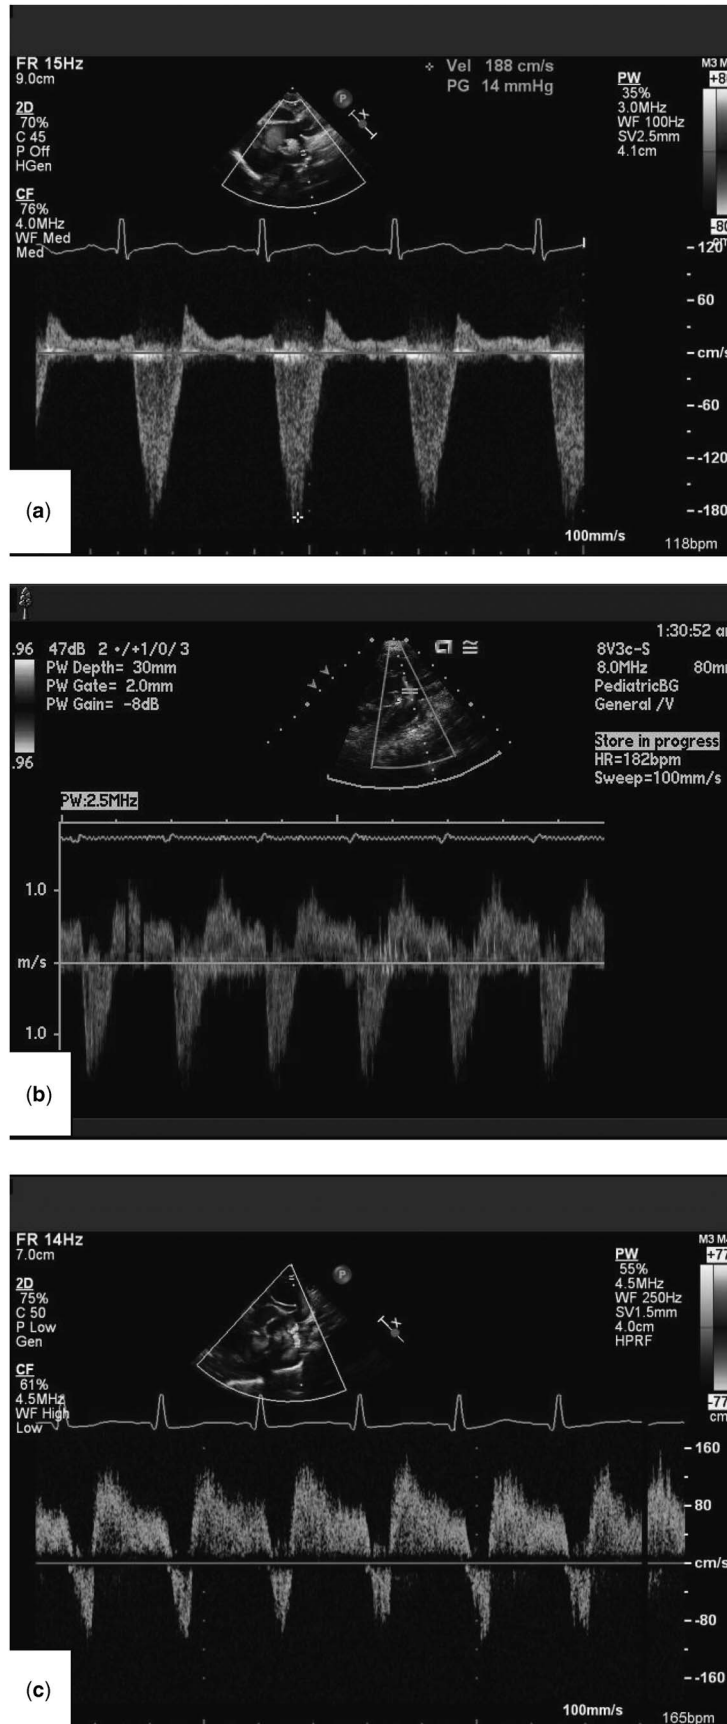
Doppler interrogation at the aortic isthmus demonstrating antegrade:retrograde VTI ratio 1.5 (a) and <1 (b,c). VTI = Velocity Time Integral.
